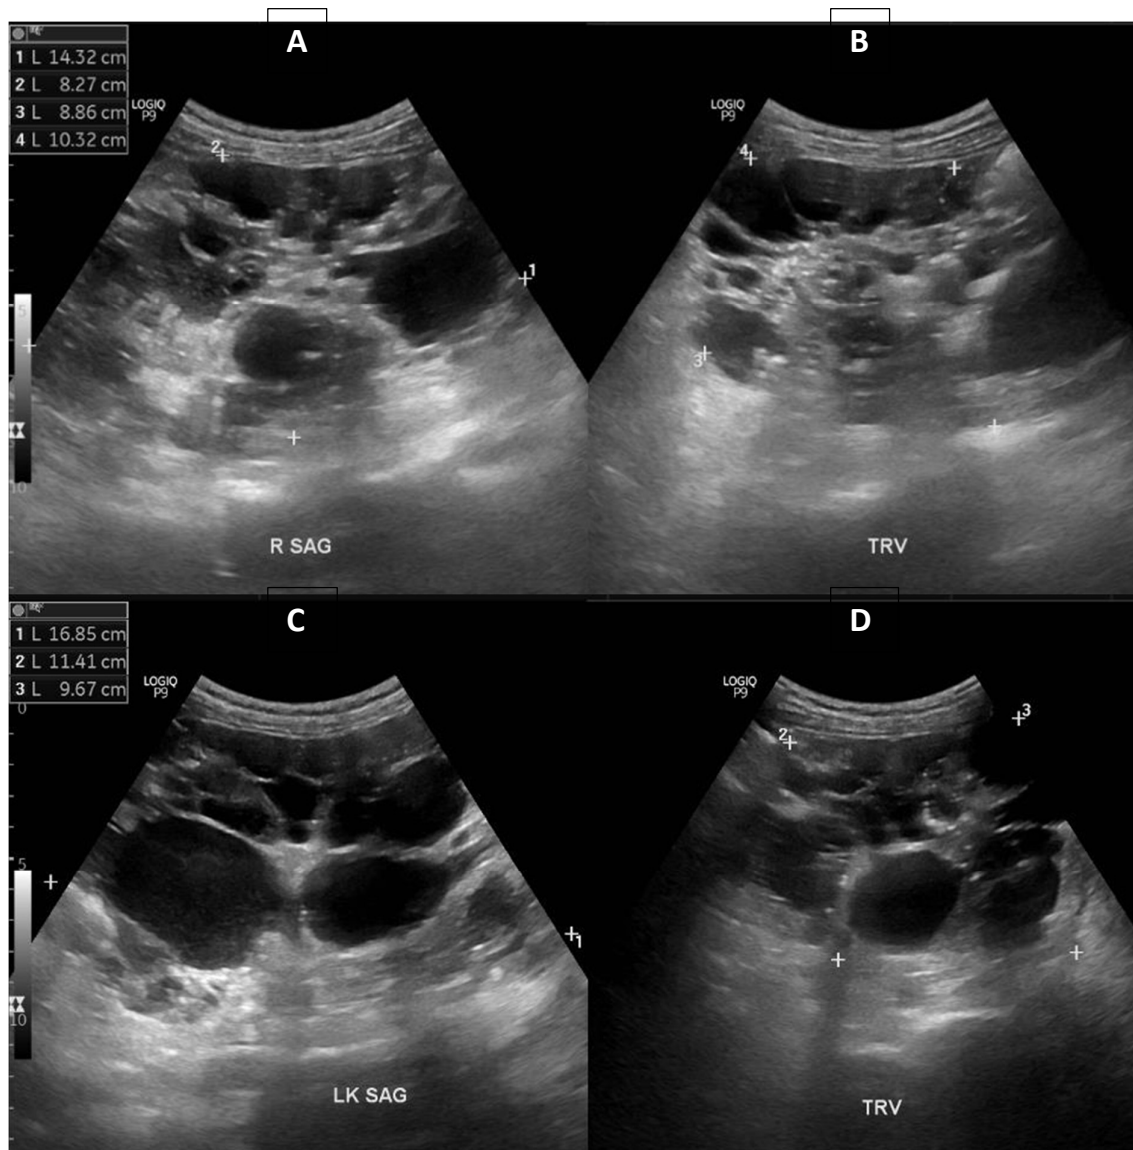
Ultrasound of the kidneys in sagittal (A,C) and transverse (B,D) planes showing multiple varisized cysts replacing the entire renal parenchyma, consistent with autosomal-dominant polycystic kidney disease.
